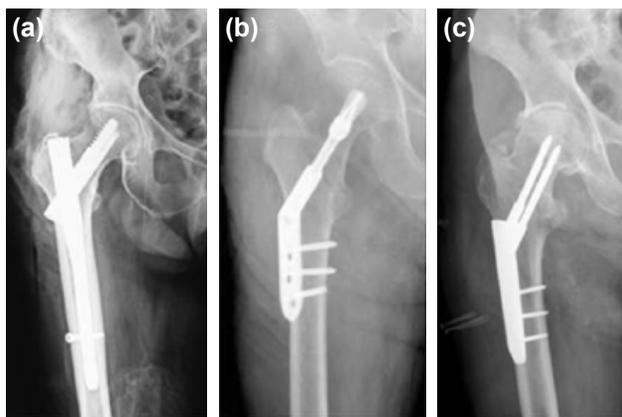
Early postoperative anteroposterior radiographic views of patients who had (a) PFNA, (b) DHS, and (c) PCCP.
